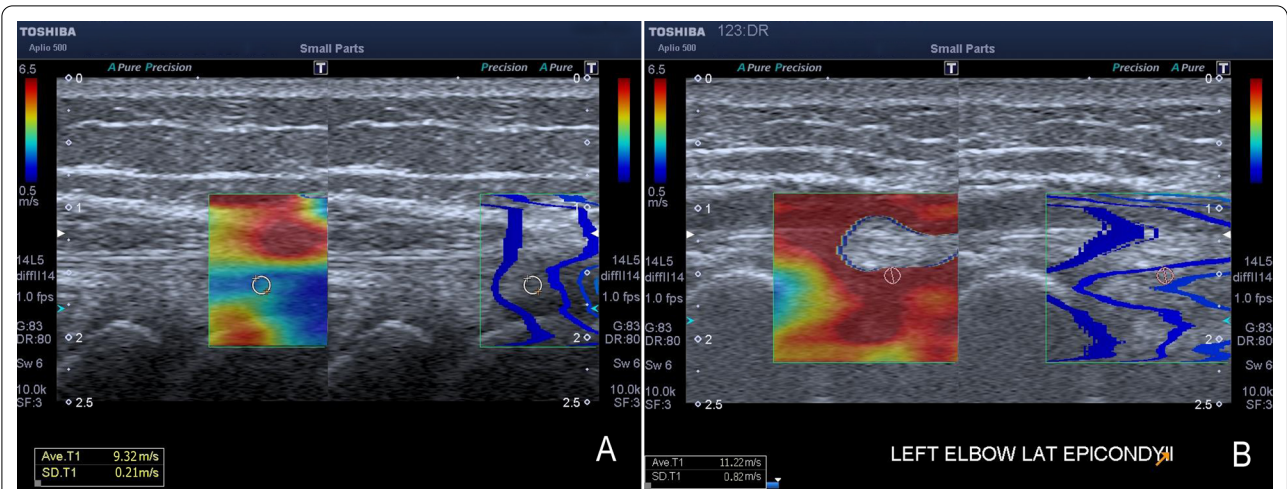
Shear wave elastography (SWE) ultrasound of the same common extensor tendon (CET) with lateral epicondylitis on longitudinal scan A before non-operative management when the patient was complaining of pain along lateral aspect of elbow joint and B after non-operative management with reduced intensity of pain in a 52-year-old male patient. The change in shear wave speed (SWS) proved that SWE could monitor the treatment effect
